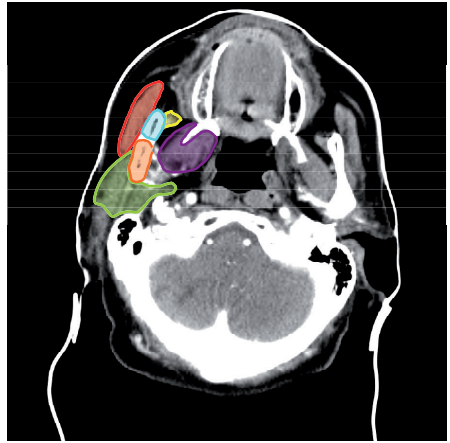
Paired mastication apparatus with structures of relevance depicted on axial CT slice.
